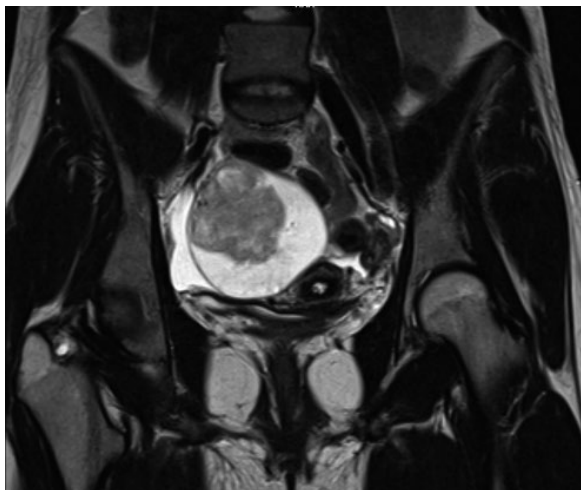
Pre-operative magnetic resonance imaging with contrast
